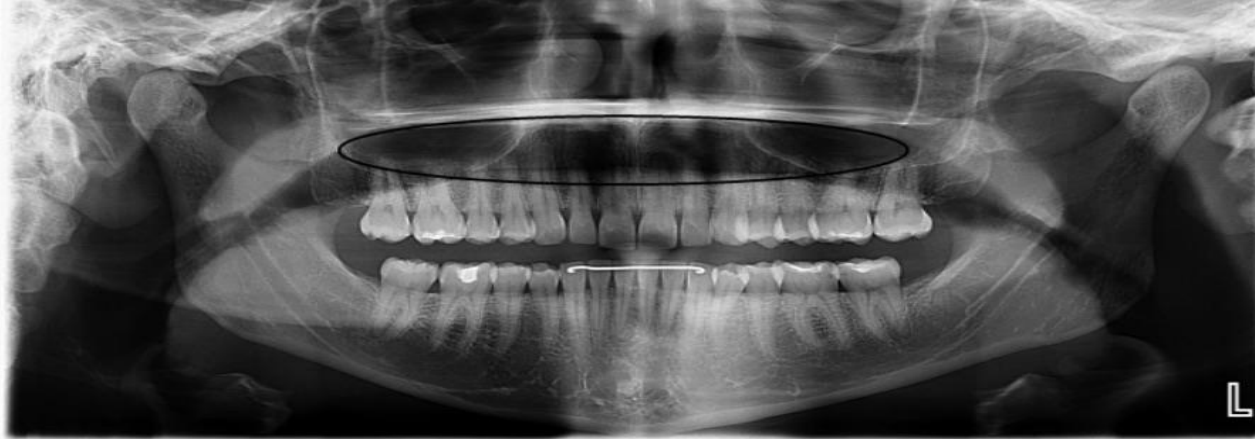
Panoramic radiograph with radiolucent artifact superimposed over the maxillary apices. The patient's tongue is not placed against the hard palate.
